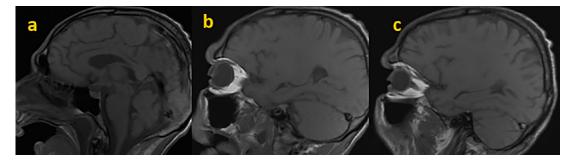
No signal abnormality on T1-weighted ponderation (a-c).
